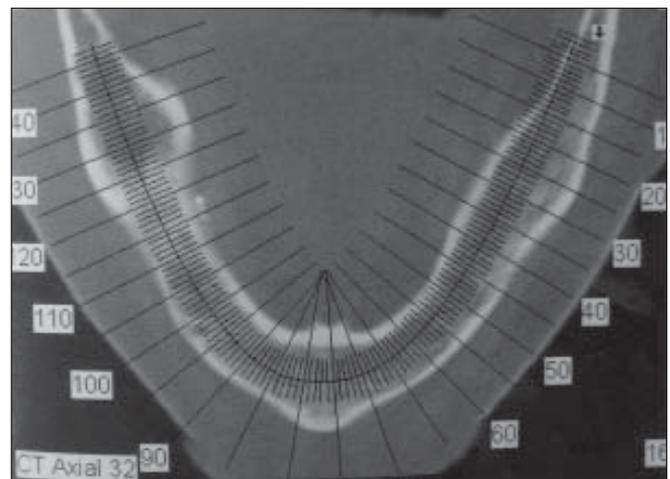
The CT image reformatted in an axial plane
